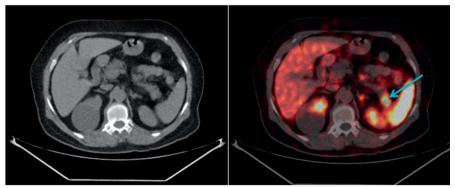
Transaxial CT and Fused PET/CT images of 63 years old male patient who underwent Ga-68 DOTATATE PET/CT for 17 mm pancreatic tail mass and elevated CrA
